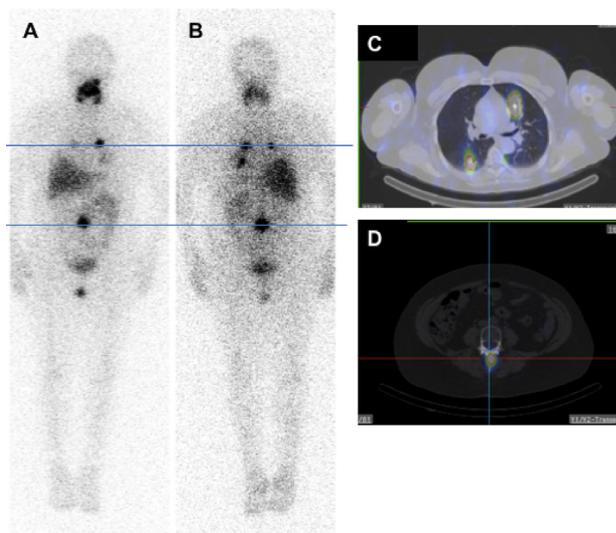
Metastatic follicular thyroid carcinoma. (A) Anterior whole body ^{131}I -NaI scan following treatment with 200 mCi of ^{131}I -NaI shows uptake in pulmonary nodules and lumbar spine, (B) posterior whole body planar image, (C) coregistered SPECT/CT image of the lung metastases. (D) Coregistered SPECT/CT imaging of the lumbar spine metastasis.
